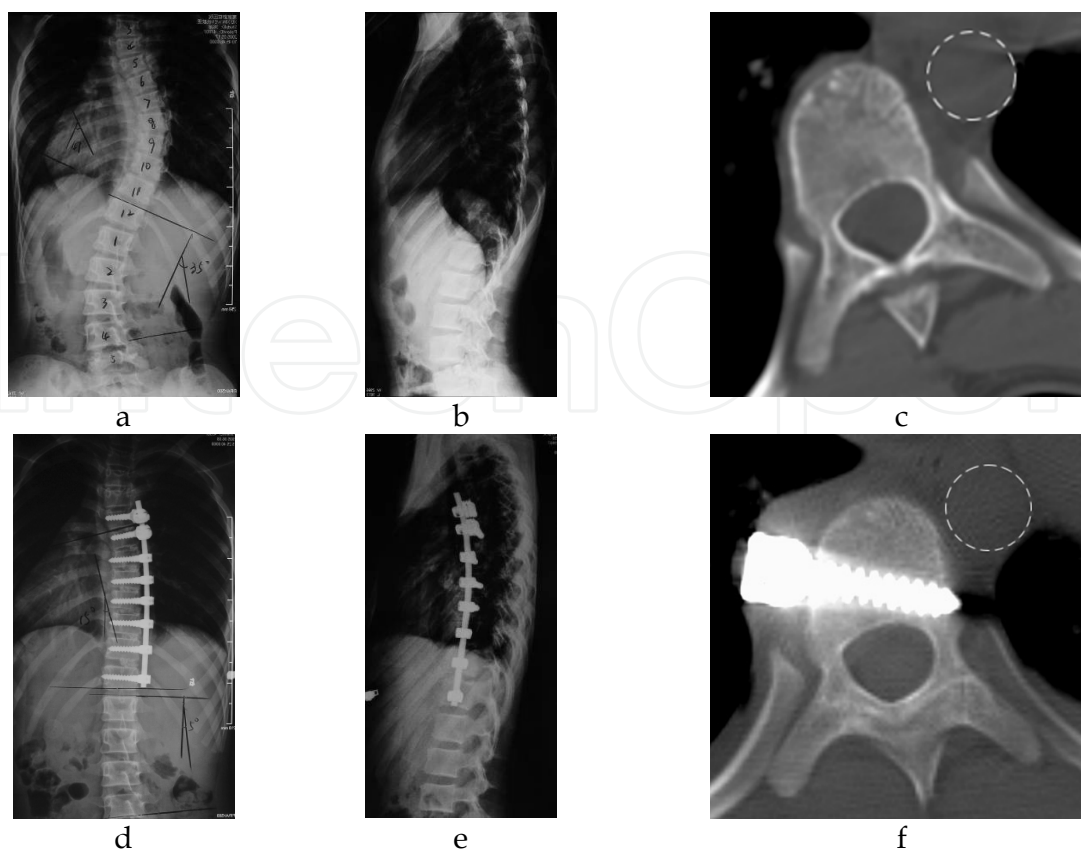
A 12-year-old girl with AIS Lenke Type 1BN was operated by mini-incision thoracotomic anterior approach. a & d: Pre and Post-operative anteroposterior X-ray; b & e: Pre and Post-operative lateral X-ray ; c & f: CT images of T8, the aorta shift antero-medially after curve correction compared with the preoperative CT images
